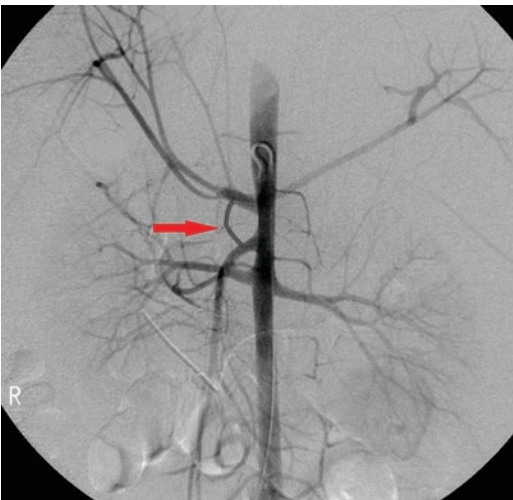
Normal CT and angiogram appearance of the superior mesenteric artery (arrows)
